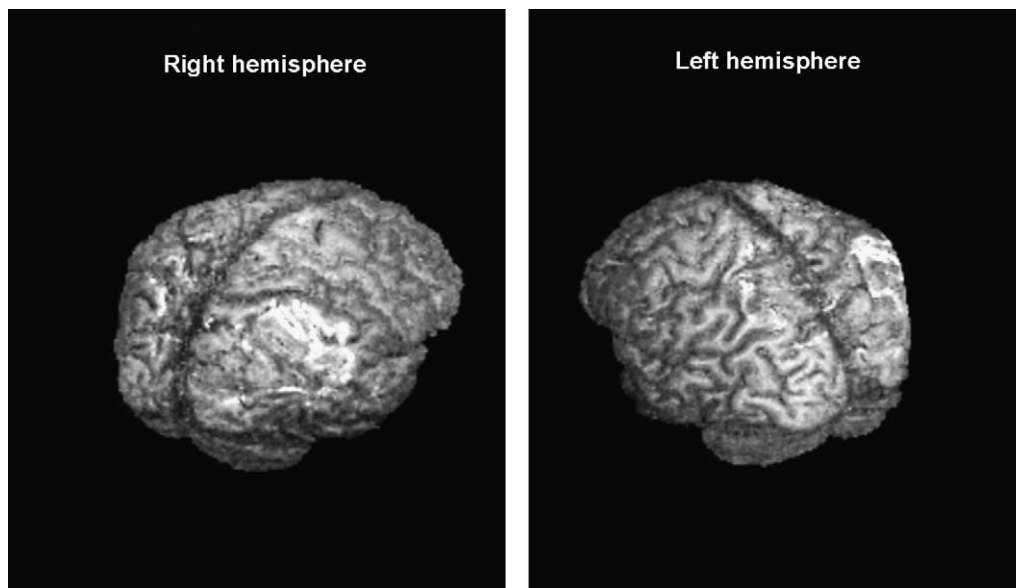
Structural MRI performed 12 weeks post-stroke showed a parieto-occipital lesion in the right hemisphere and a lesion of the dorsolateral portion of the parietal lobe in the left hemisphere. The lesion was more extended and more posterior in the right than in the left hemisphere. Note that primary somatosensory cortex in the post-central gyrus was spared on both sides, consistent with a lack of clinical tactile deficit in the patient.
